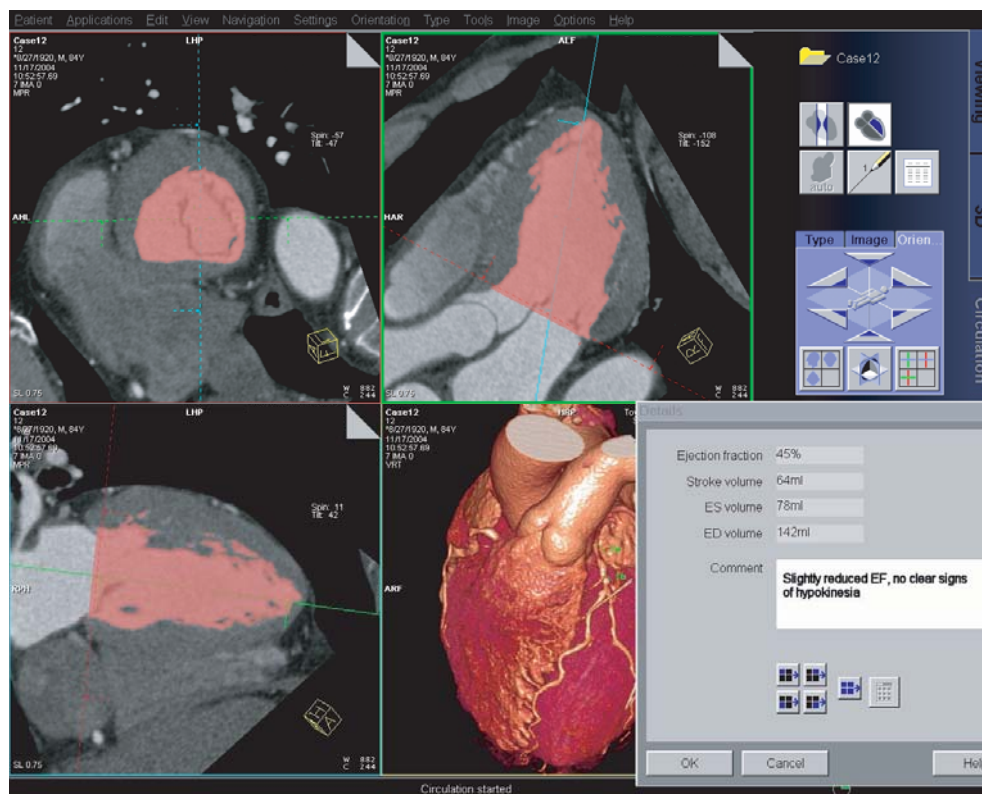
Functional evaluation in a patient with a significant LAD stenosis, examined with a 64-slice CT scanner with 64×0.6 -mm slices per rotation. The evaluation was done using comprehensive slice-based cardiac evaluation software. Thin-slice axial images in different phases of the cardiac cycle are needed as an input. Following manual definition of the basal plane in end-systole and end-diastole, the blood pool in the left ventricle is automatically segmented to allow calculation of end-systolic and end-diastolic volumes, stroke volume, and ejection fraction. The papillary muscles are excluded in this approach. (Case courtesy of Toyohashi Heart Center, Japan)
